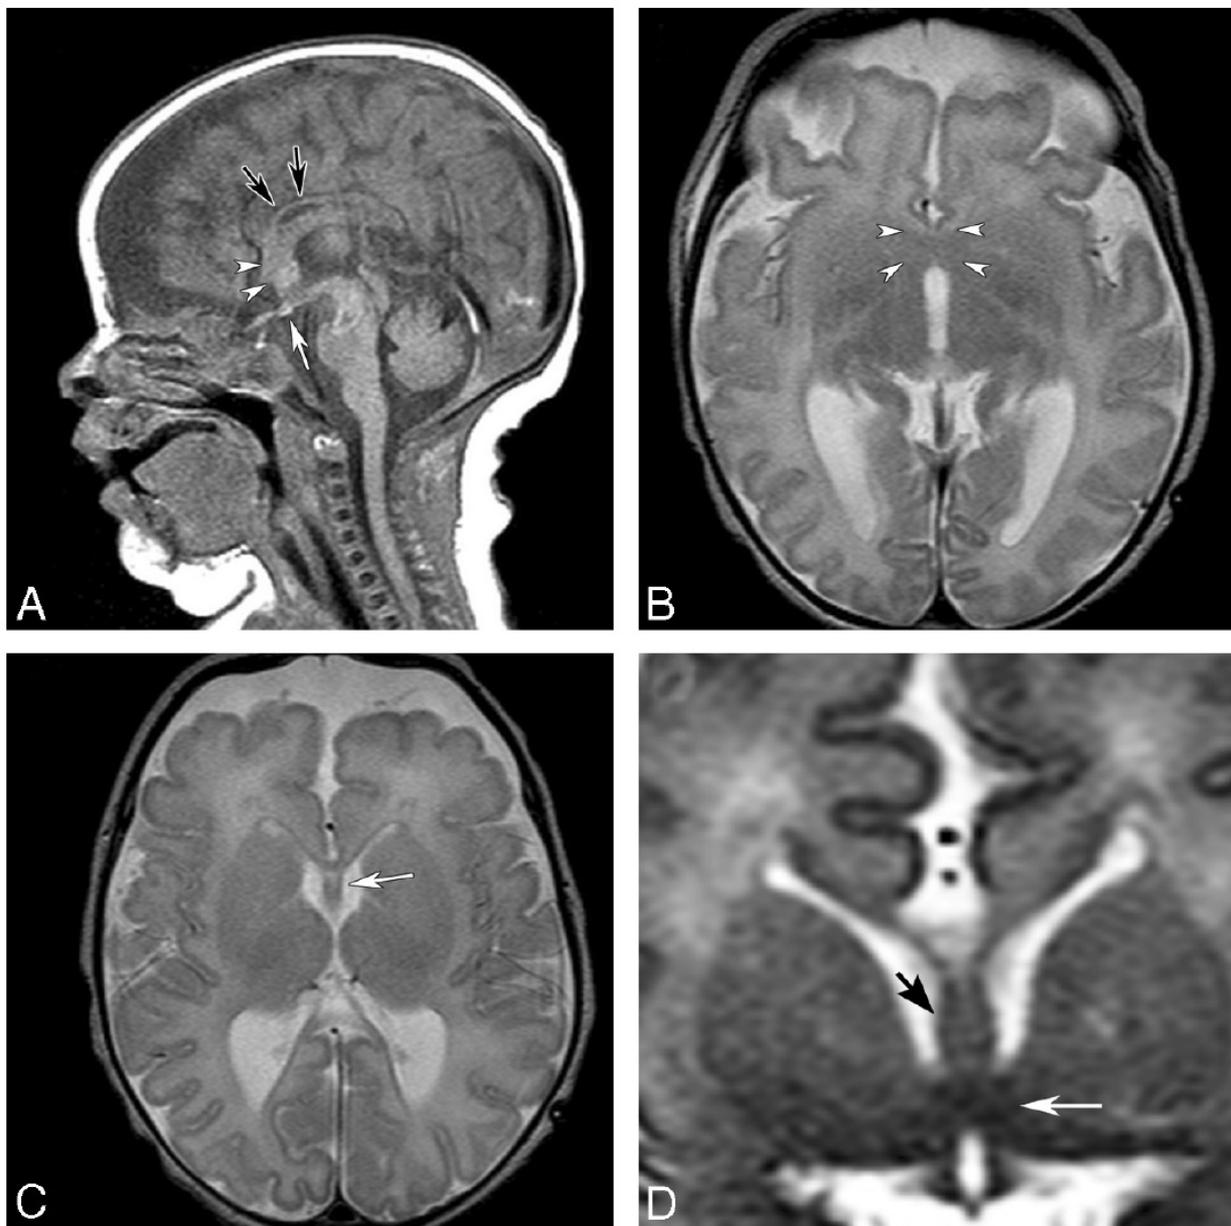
MR imaging of an 8-day-old term neonate with atrial and ventricular septal defects and SMMCI. *A*, Sagittal T1-weighted image shows a thin CC (*black arrows*), a thickened fornix, and dysplastic subcallosal areas (*arrowheads*). A small ectopic pituitary gland is noted near the chiasm (*white arrow*). *B*, Axial T2-weighted image shows an area of fusion in the septal and preoptic regions (*arrowheads*). *C*, An azygous ACA is present in the anterior IHF. Axial T2-weighted image slightly superior shows the presence of the SP (*white arrow*) and a thin genu of the CC. *D*, Coronal T2-weighted image at the level of the AC shows fusion of the midline region (*white arrow*) below the fornices (*black arrow*).
